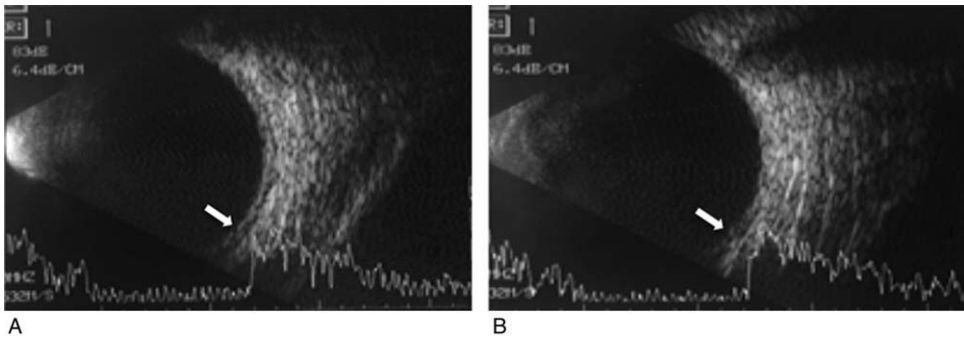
B-scan ultrasonographic images acquired at presentation showing peripheral choroidal effusions (white arrows) in the right (A) and left (B) eyes.
